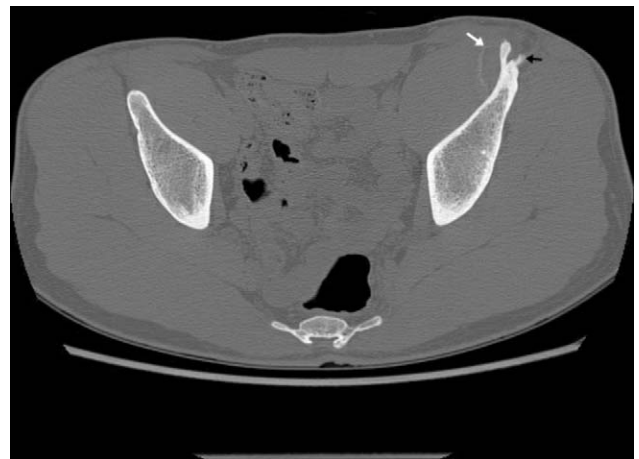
Axial CT scan of the pelvis showing the avulsion fracture of the left anterior superior iliac spine (black arrow) and the hematoma (white arrow).
